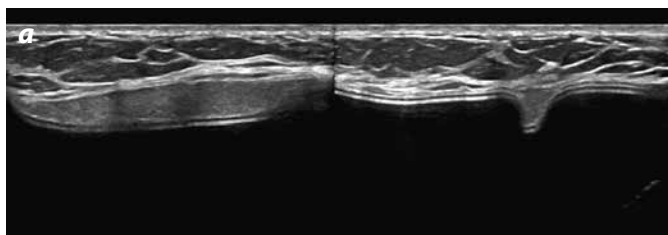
Intracapsular rupture. a) Breast ultrasound, sign of the "echogenic folding" in longitudinal and transversal planes. b) Breast MR, T2-STIR coronal image with water saturation: sign of the "lock" (arrow); sign of the "subcapsular line" (head of arrow) and water drop at the interior of the prosthesis (\*).
